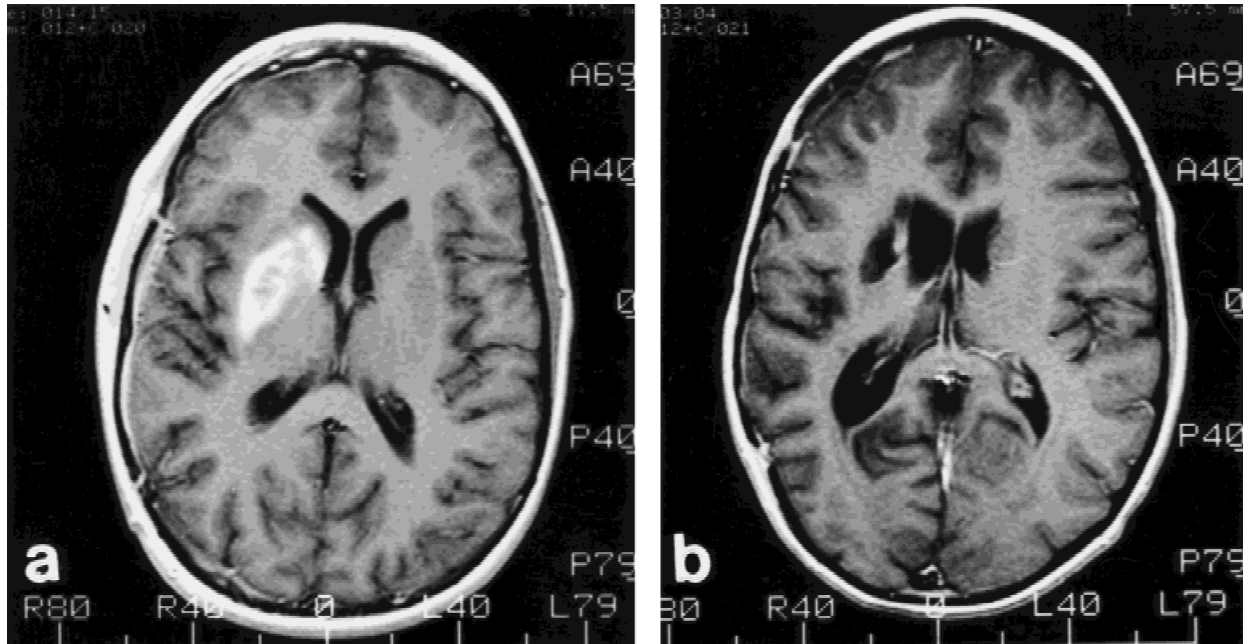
a: Postoperative axial T1-weighted MRI with Gd-DTPA contrast of patient 13 reveals a contrast-enhancing mass in the region of the right basal ganglia with minimal mass effect. b: Following four courses of chemotherapy, a near-total resolution of contrast-enhancing mass has been achieved, leaving a residual cavity.
